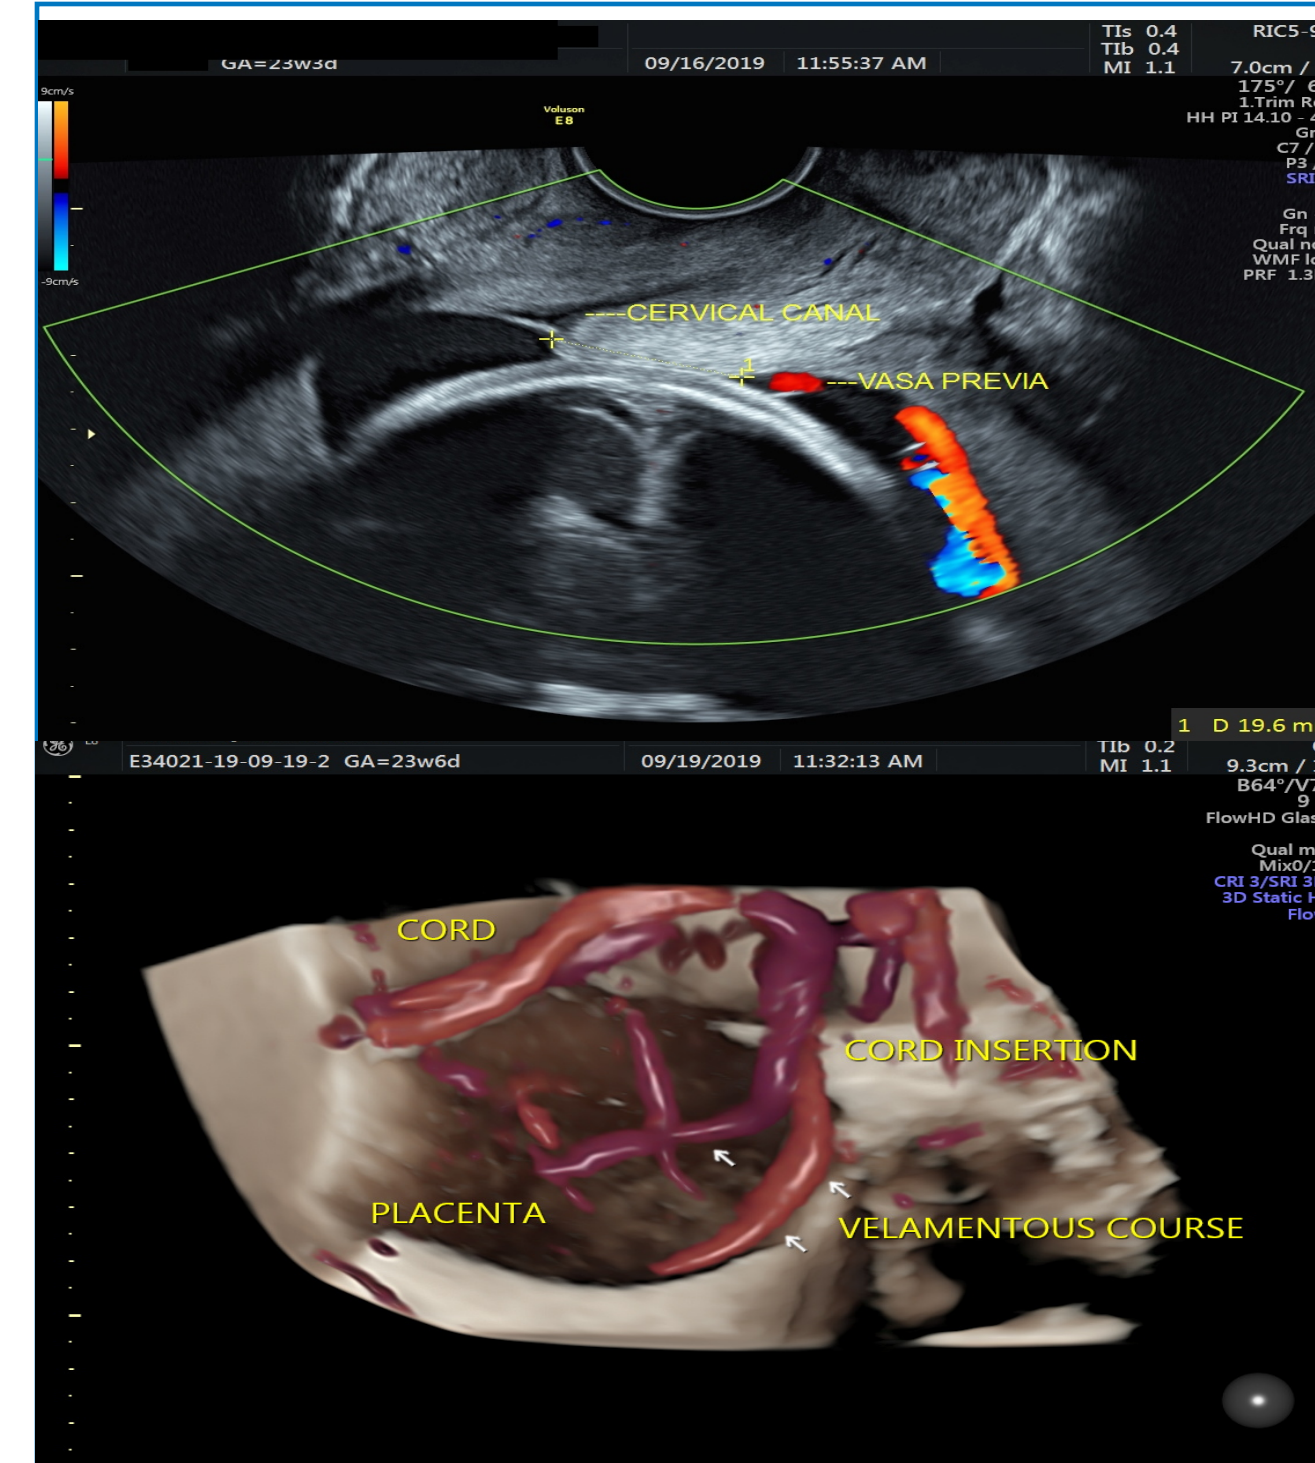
Color Doppler's and 3D rendering of velamentous insertion and vasa previa
